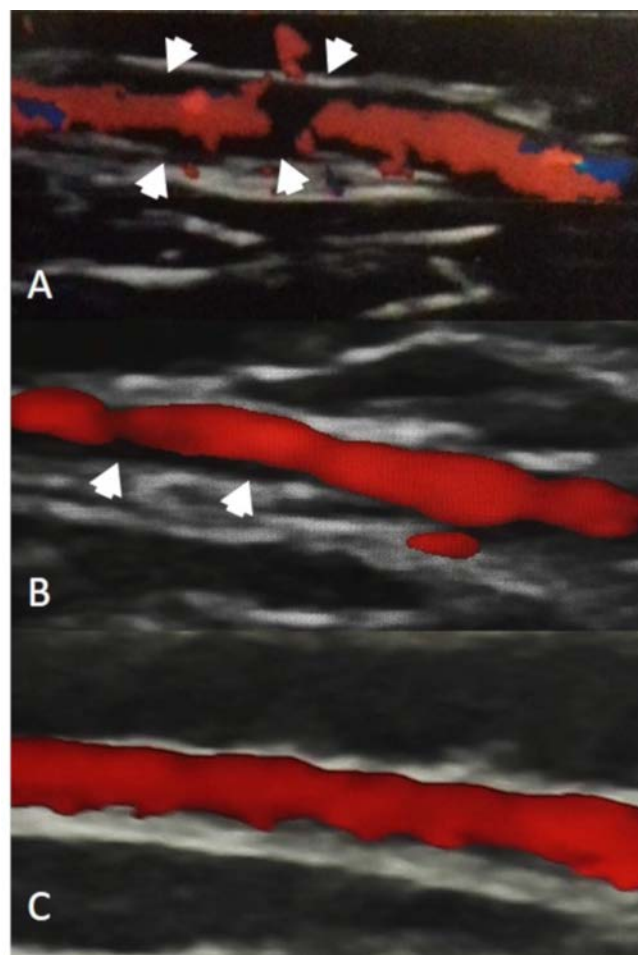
Ultrasound of the right superficial common temporal artery (longitudinal view) at baseline (A), 3 months later (B) and 12 months after (C) consecutive tocilizumab treatment. At baseline (A), a dark hypoechoic area can be noted at the vessel wall (arrows). Three months later, the 'halo sign' has been improved (B) and after 12 months it has almost disappeared (C). Meanwhile, serum inflammation markers and patient's symptoms have significantly improved. A linear probe (12 L), 12 MHz (grey scale) and 6.7 MHz (colour Doppler) frequency were used.
